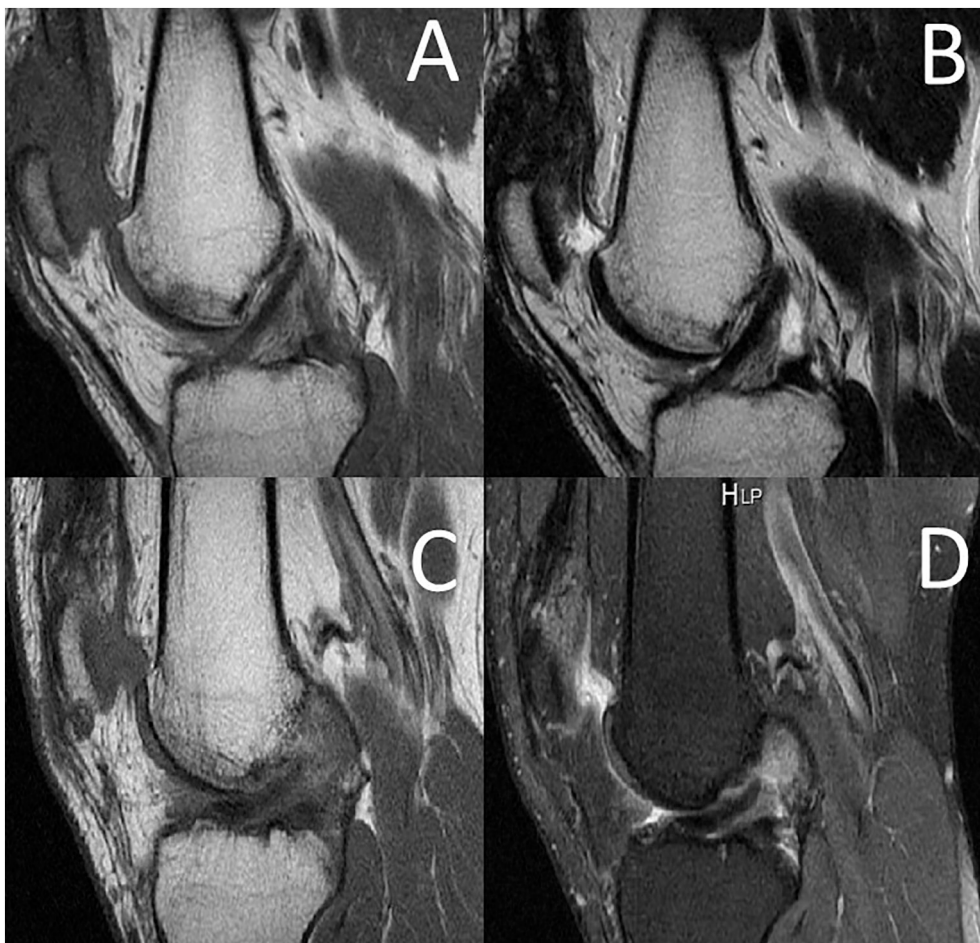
Legend: Left knee sagittal MRI T1 (A), and T2 sequence (B) demonstrating a normally appearing left ACL. Right knee sagittal MRI T1 (C), and PD sequences (D) showing an injured ACL.
